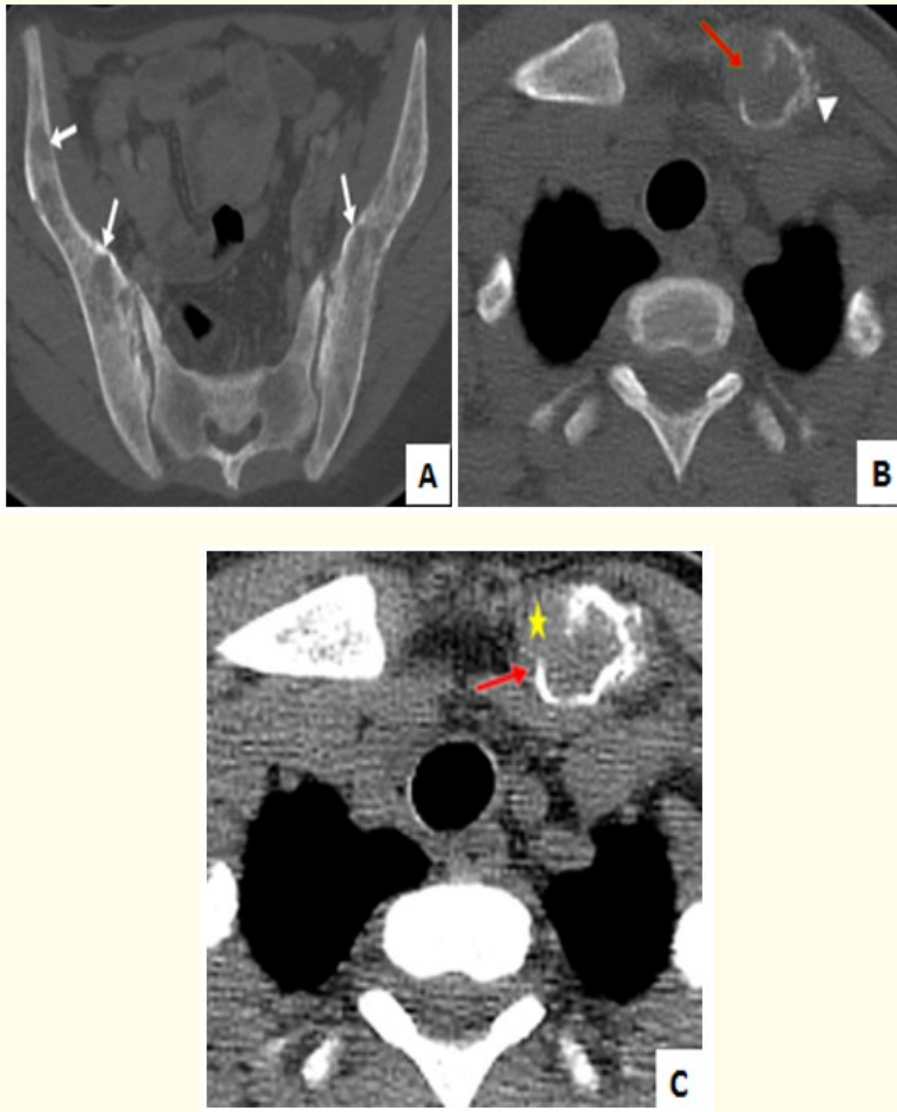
Computed tomography images, in axial sections, with bone (A and B) and parenchymal (C) windows.
